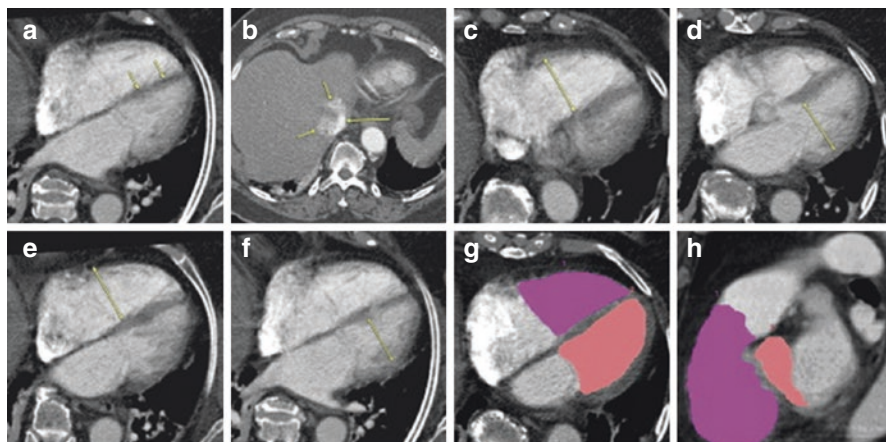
Computed Tomography in a patient with acute pulmonary embolism. (a) Four-chamber view reconstruction with septal flattening (arrows). (b) Grade 4 reflux of contrast into the inferior vena cava (long arrow) and proximal hepatic veins (short arrows). (c) The maximal diameter on axial sections of (c) right and (d) left ventricular diameter. (e) The maximal diameter on four-chamber view of the right and (f) left ventricle. Right and left ventricle volumetric depicted on (g) axial section and (h) sagittal reformation. Reprinted with permission from “CT Signs of Right Ventricular Dysfunction: Prognostic Role in Acute Pulmonary Embolism” by Doo Kyoung Kang et al., *JACC Cardiovasc Imaging* 2011; Volume 4:8:841–849. Copyright (2017) by Elsevier Inc.
